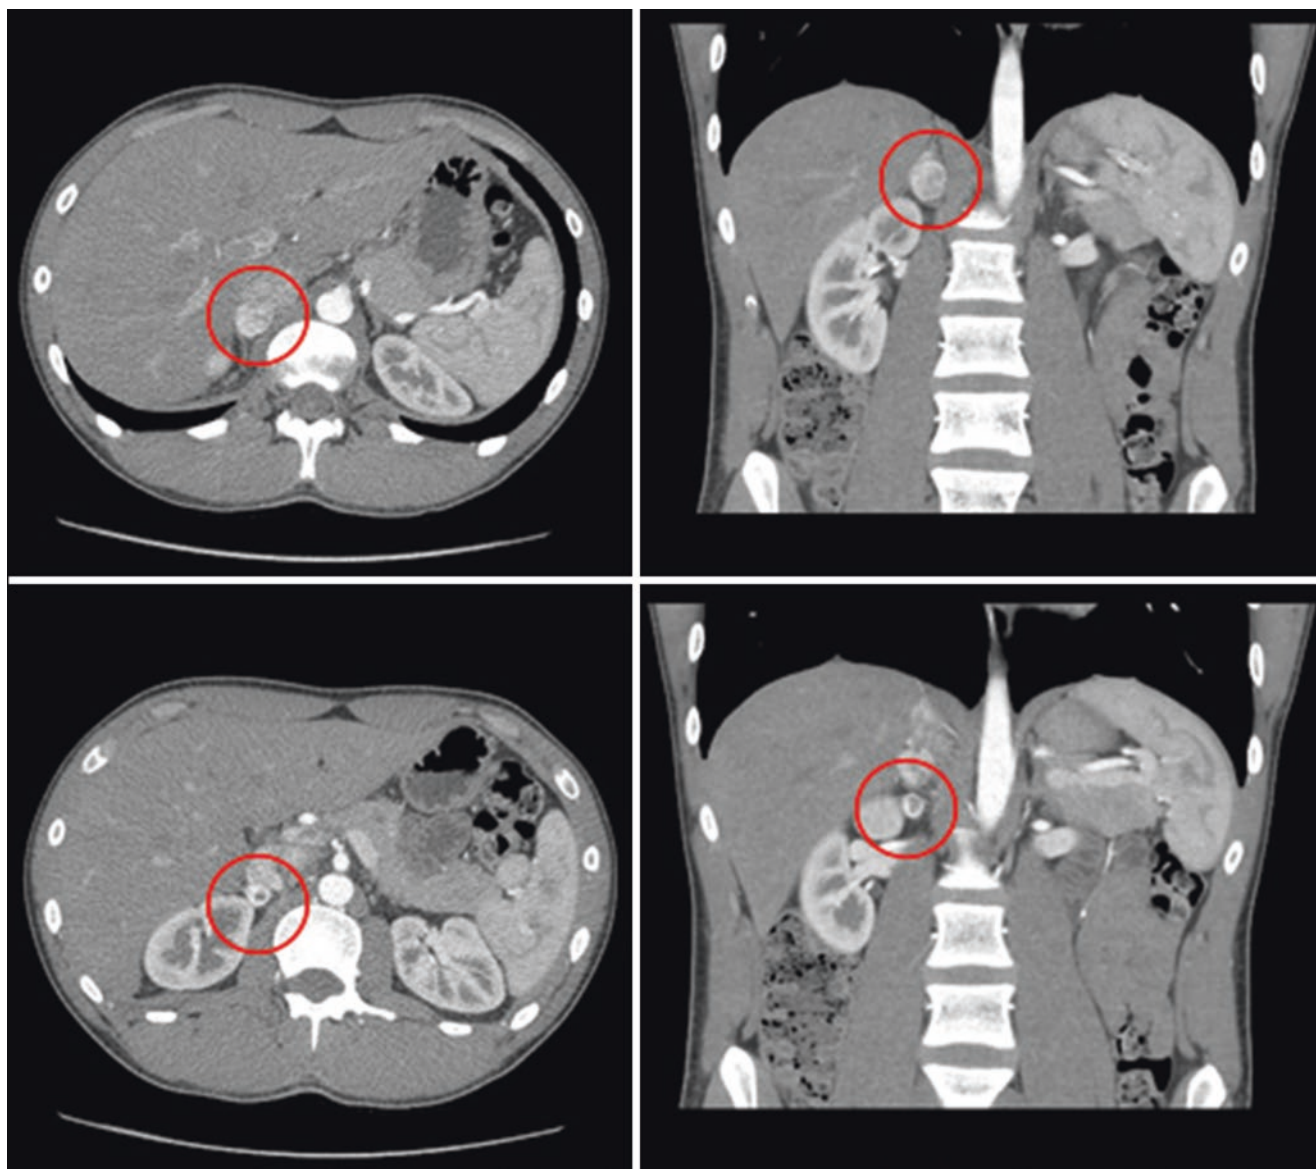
Computed tomography, contrast-enhanced imaging, with two distinct nodules in the right adrenal gland, indicated by the red circles
